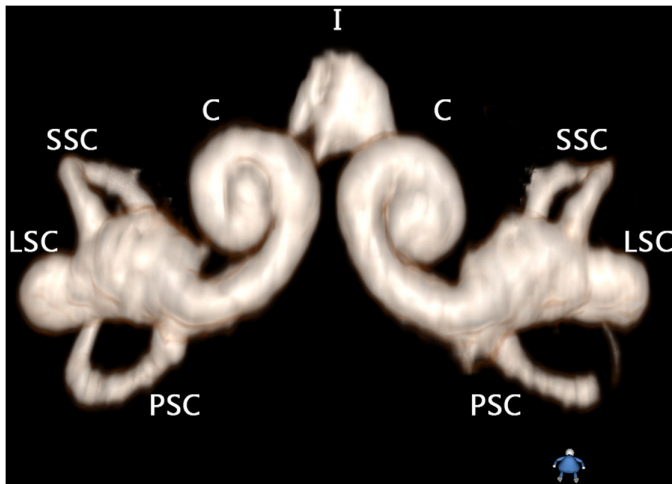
Coronal 3D view of the MR image. Abbreviations: C, cochlea; I, internal acoustic canal; LSC, lateral semicircular canal; PSC, posterior semicircular canal; SSC, superior semicircular canal.
